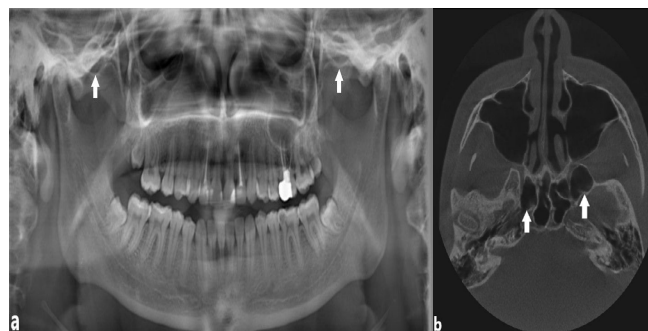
Bilateral sphenoid sinus pneumatization (SSP) on the right and left zygomatic arch in the panoramic image (a) and axial cone-beam computed tomography image (b).
